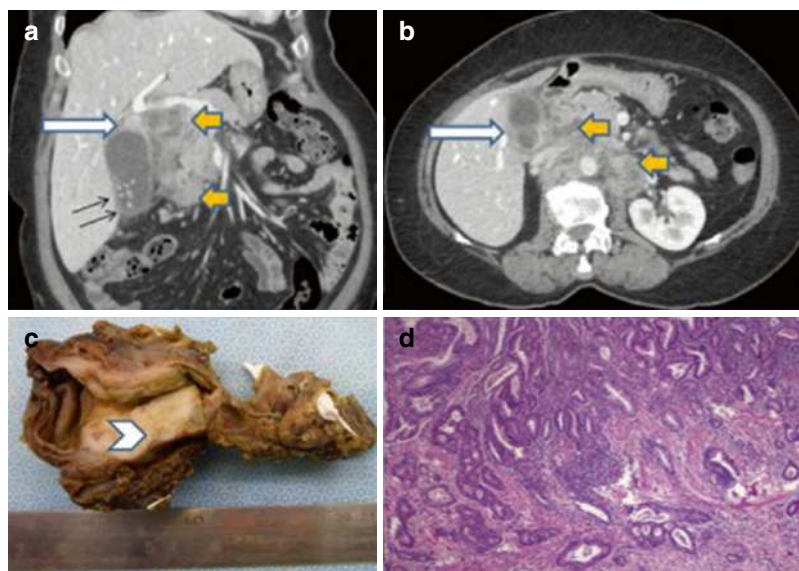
Contrast-enhanced CT and radical cholecystectomy with lymph node dissection: (a, b) Coronal and axial CT images reveal cholelithiasis (black arrow) with annular mural thickening in the gallbladder neck region (white arrows) and periportal/peripancreatic, pre-/para-aortic lymphadenopathy (yellow arrows) (c). Photograph
